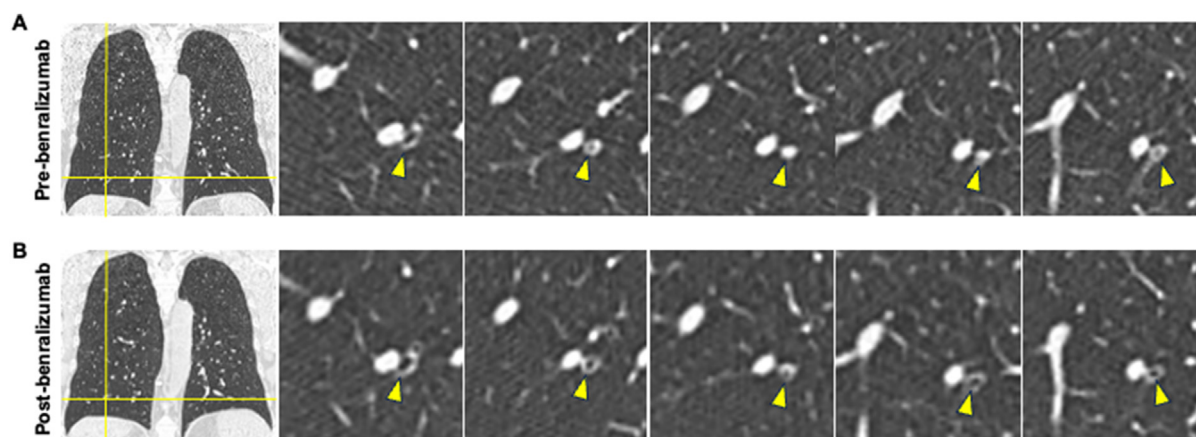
CT images of mucus before and after treatment with benralizumab. Panel A and B show sequential axial images through the left lower lobe of a patient before and after treatment with benralizumab. In Panel A, the yellow arrows indicate complete opacification of a subsegmental airway developed in sequential imaging of the RB9 segment. In Panel B, the yellow arrows correspond to the same images as in A, revealing a complete resolution of the mucus plug at 1-year follow-up imaging.
